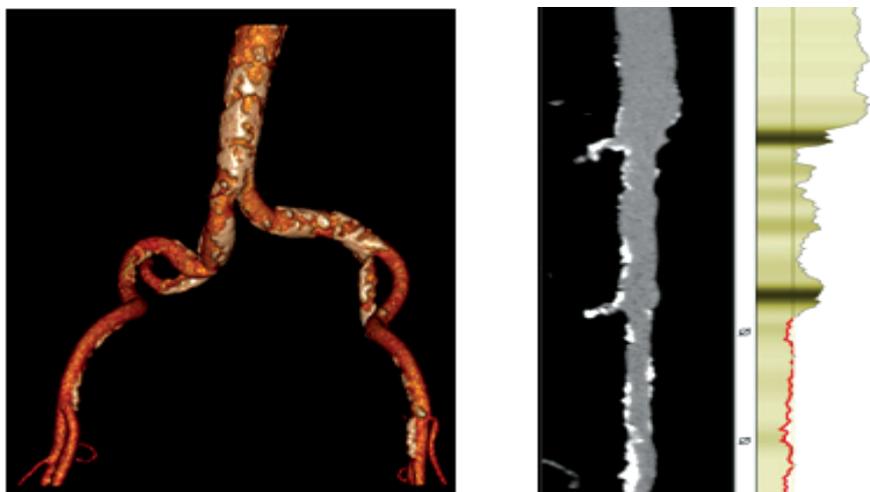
Three-dimensional reconstruction of contrast-enhanced CT angiography to assess morphology of femoral arteries (left) and centerline stretched view (right)
